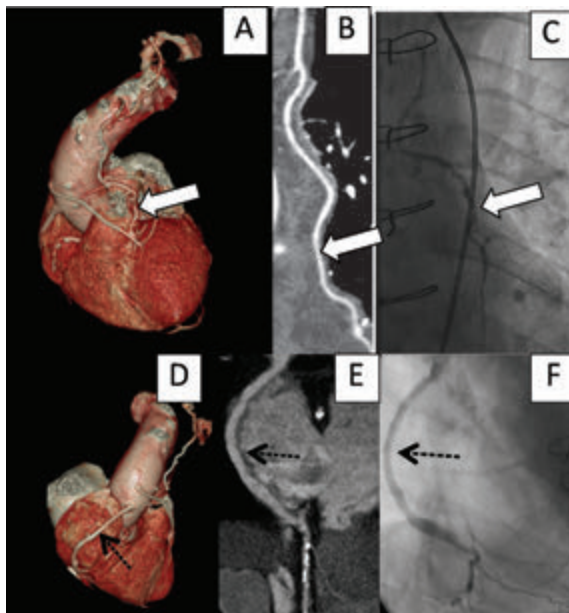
A 62 year-old-man with recurrent chest pain after coronary artery bypass graft surgery 5 years earlier. CCTA volume rendering technique image (A, D) and curved multiplanar reformation image (B, E) showed patent LIMA to distal LAD (arrows) and patent SVG to distal RCA (dashed arrows). Corresponding conventional coronary angiogram (C, F) confirms CT findings (arrow and dashed arrow) (LIMA = left internal mammary artery; LAD = left anterior descending artery; SVG = saphenous vein graft; RCA = right coronary artery).
